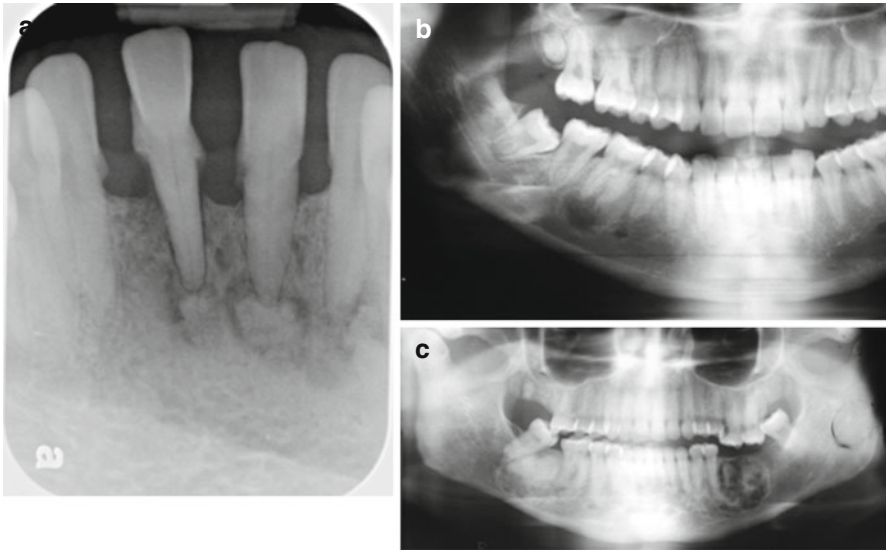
(a) Periapical cemento-osseous dysplasia appears as mixed radiopaque and radiolucent lesions at apex of anterior teeth. (b) A radiolucent periapical cemento-osseous dysplasia lesion associated with tooth #30. (c) Mixed radiopaque and radiolucent lesions involving the entire lower jaw with periapical cemento-osseous dysplasia lesions
